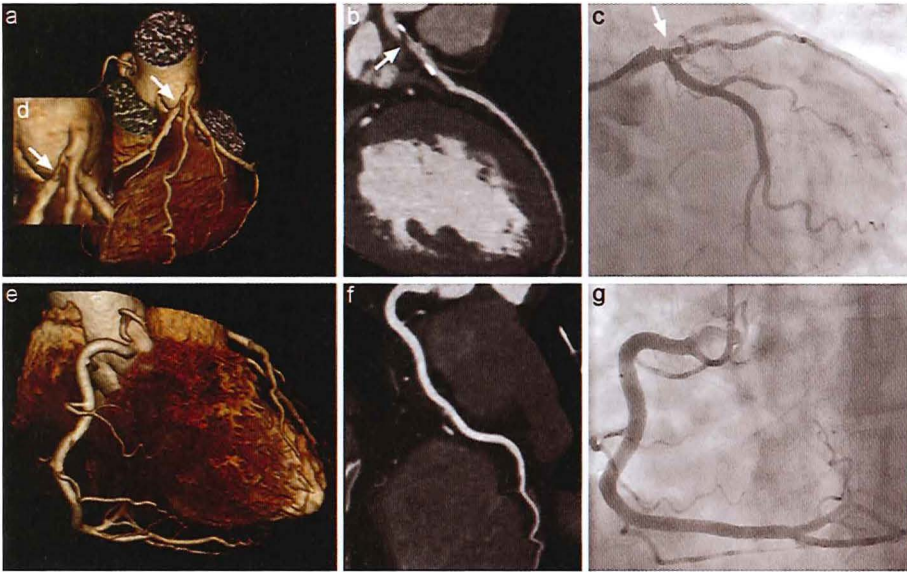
Prospective sequential CT coronary angiography protocol with a wide CT data acquisition window in a patient with a high heart rate. Male, 57 years old, presenting with atypical angina pectoris and a positive exercise test. Mean heart rate during CT was 74 bpm. Estimated radiation dose of the wide window sequential CTCA protocol was 3.9 mSv. Volume rendered CTCA images (VRT) reveal the anatomy of the left anterior descending coronary artery (LAD) (a) and the right coronary artery (RCA) (e). The curved multiplanar reconstruction image (cMPR) (b) and the VRT inlay (d) disclose a subtotal occlusion (arrow) of the proximal LAD, which was confirmed by CCA (c). The cMPR image (f) shows a non-diseased RCA which was confirmed by CCA (g).
